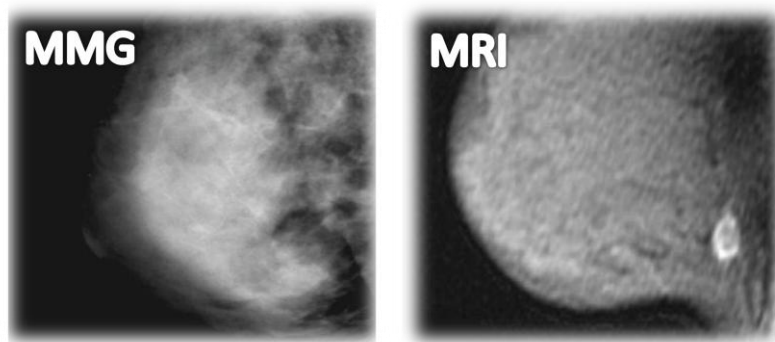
Mammographically (MMG) occult breast cancer detected in the carrier of a *BRCA2* mutation on magnetic resonance imaging (MRI) [adapted from: Robson (2007)].
